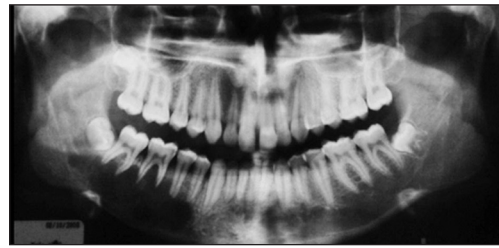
The preoperative panoramic radiograph which shows large radiolucent area of an arterio-venous malformation at the right posterior side of the mandible.
